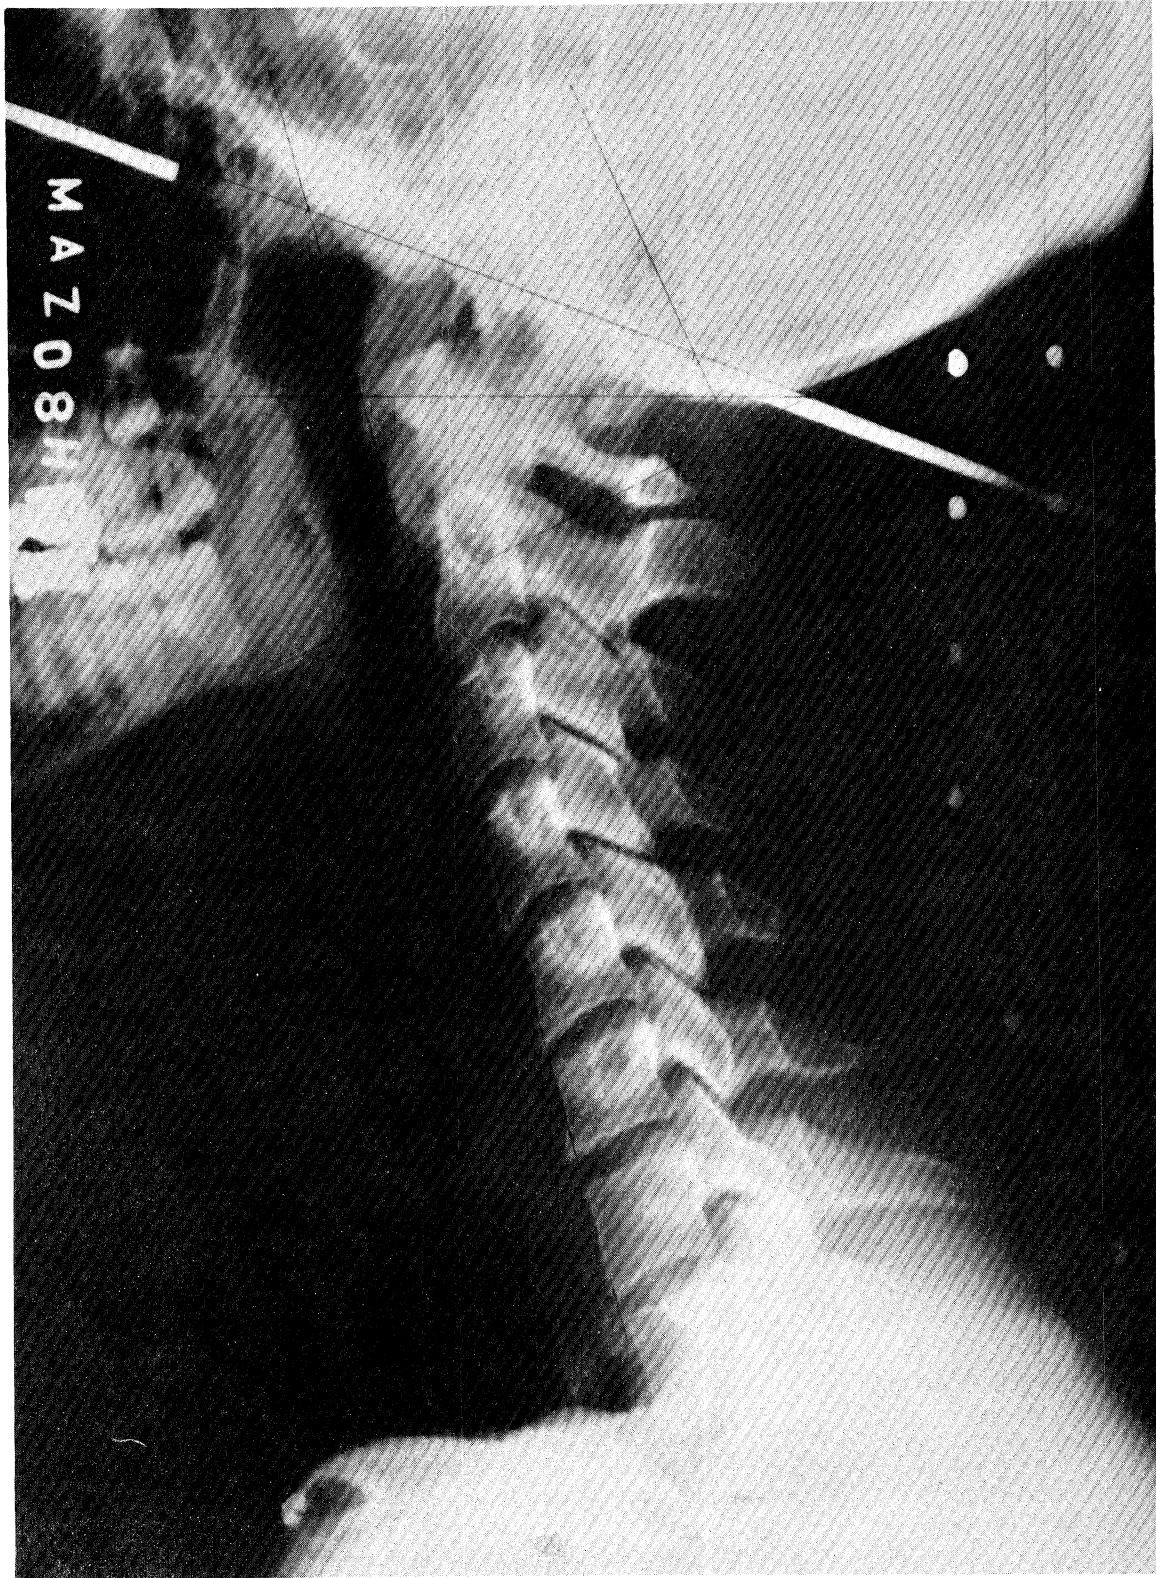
Lateral X-ray of Subject in Neutral Position (Hard Seat). Note Lead Markers at C-5 and C-7, Rod Positioned on Nasion-tragion Line, and Verticality Marker. Head Position can be Established by the Angle Between the Rod and Horizontal and also by the Angle Between Horizontal and a Line Drawn from the Occipital Protuberance Tangent to the Base of the Skull.
